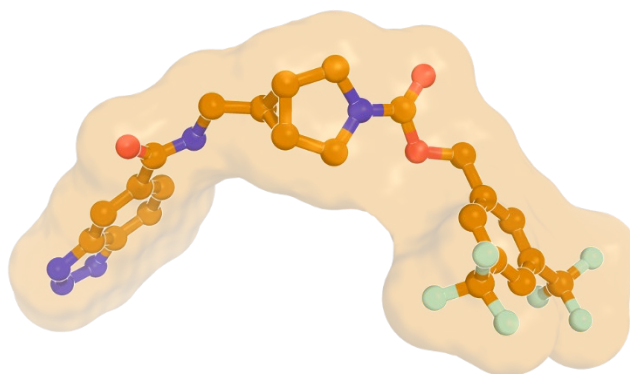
3D structure of BI-2545, 3D conformation as observed in the X-ray structure of the complex with ATX (see Figure 3)
